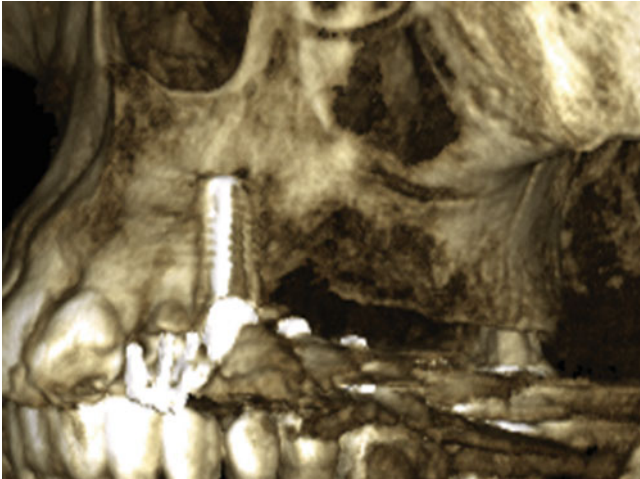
CBCT 3D reconstruction of left maxillar implant
